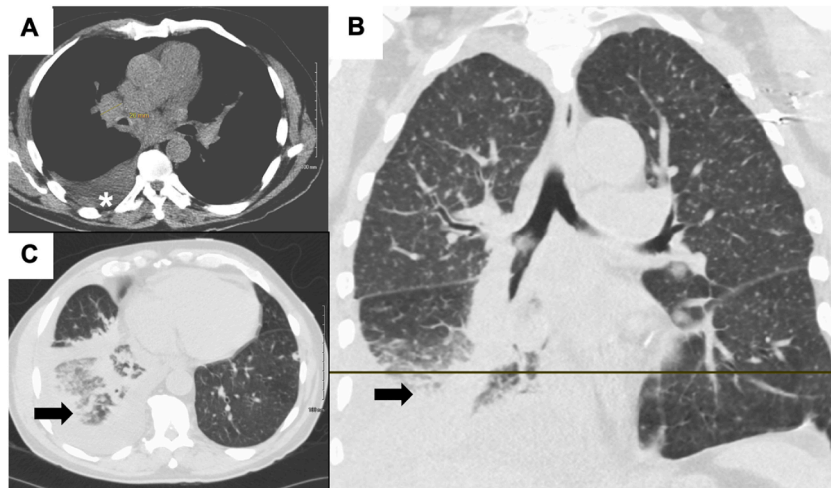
Chest CT scan Without Contrast on Admission. (A) Axial CT image (Soft-tissue window) showing a right pleural effusion, marked with an asterisk (*). (B) Coronal CT section (Lung window) demonstrates diffuse micronodular opacities bilaterally along with consolidation in the right lower lobe (Black arrow). A black horizontal line indicates the cut level depicted in Image (C) corresponding to the Axial view (Lung window), highlighting the consolidation process surrounding atelectatic lung (Black arrow).
